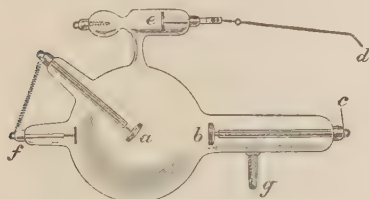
Vacuum tube. *a*, Anode or + pole from which the X-rays are given off; *b*, cathode or - pole; *c*, *d*, arrangement for connecting the cathode temporarily with *e*, a mica plate, in order to counteract hardening; *f*, extra anode; *g*, sealed exhaust tube.
